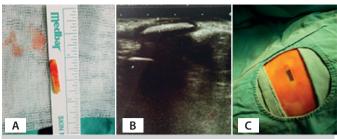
A. Extracted foreign body B. Ultrasound image of wooden foreign body C. Longitudinal axis of foreign body marked on the skin by the radiologist.
